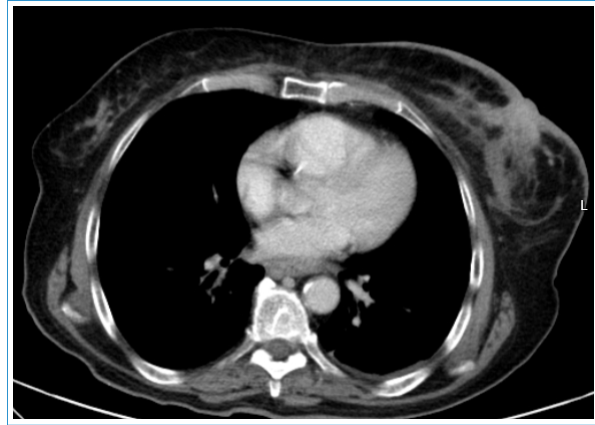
Thoracic computed tomography showing, on the left breast, an irregular and hyperdense retroareolar lesion, measuring approximately 6 cm, with associated skin thickening.
